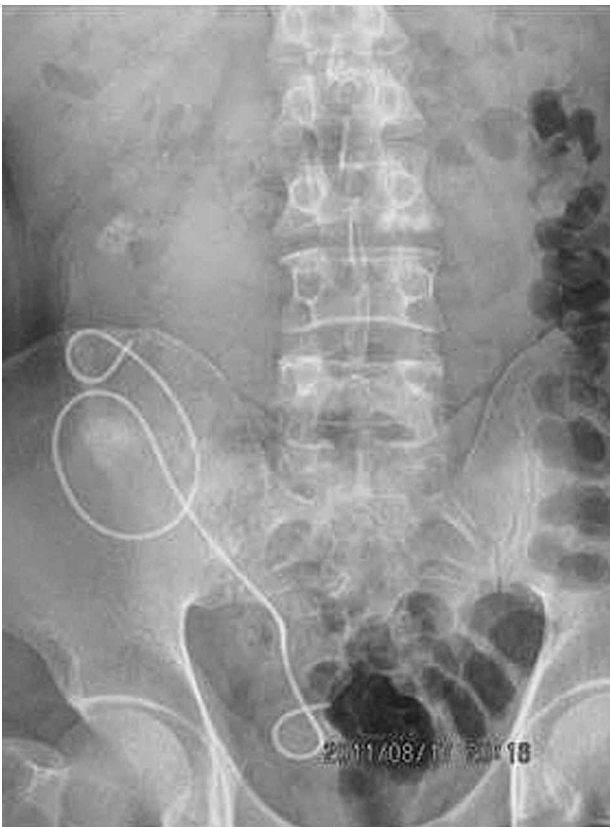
Plain abdominal X-ray (Kidney-Ureter-Bladder [KUB]) revealed no stone fragment and DJ in ectopic kidney.
